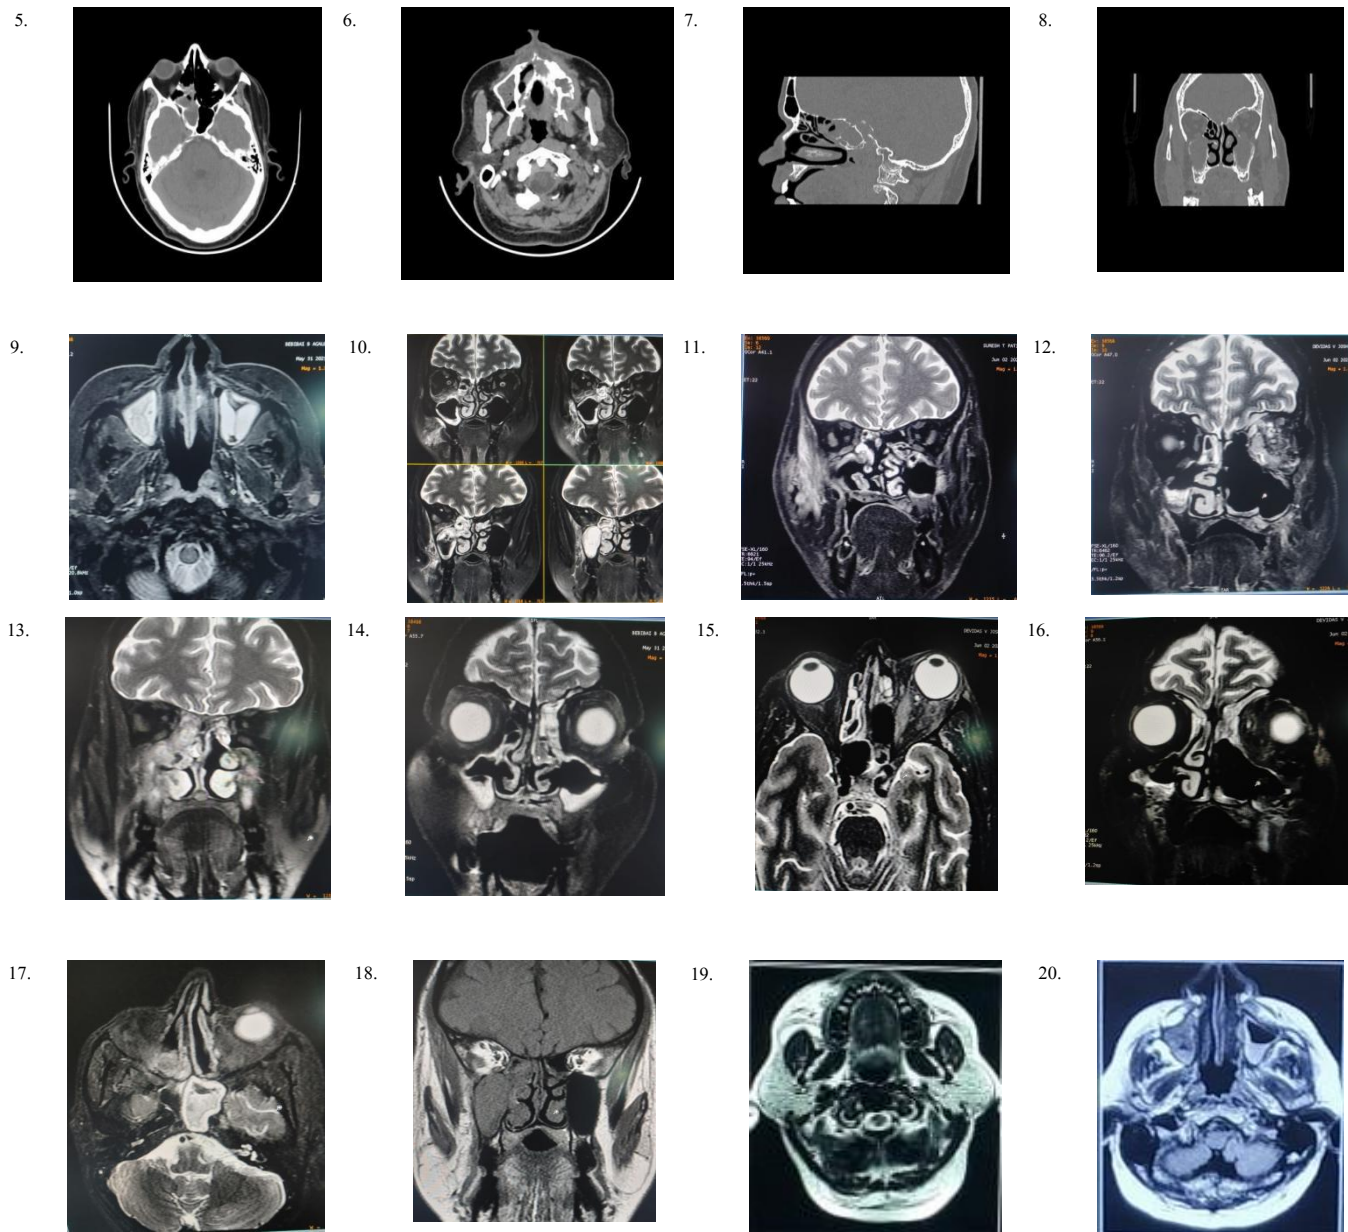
CT and MRI Imaging
